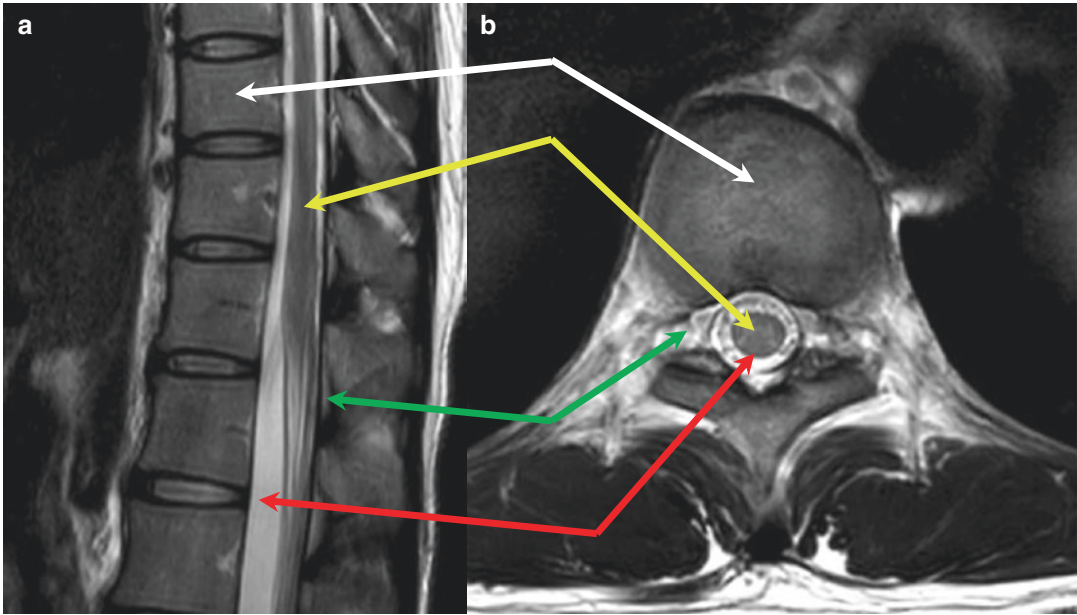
The concept of compartmental locations of the spine on the T2-weighted magnetic resonance (MR) images, sagittal (a) and axial (b) scans. The compartments are
